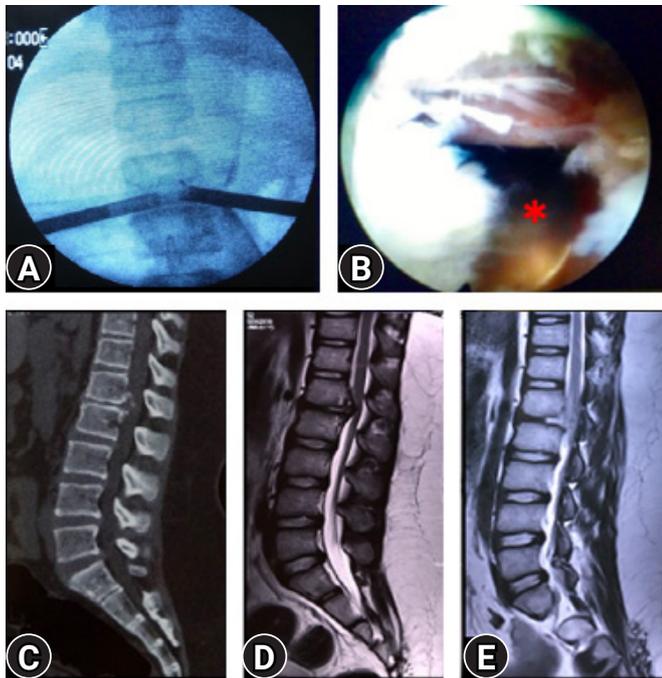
(A) Image intensifier view of a bilateral transforaminal endoscopy with two working ports. (B) The one side view showing the opposite working sheath with removed ventral stenosis and with neural fall back suggesting the EPD (End point decompression). (C, D) CT scan and MRI showing calcified ventral disc and posterior longitudinal ligament in a case for Conus syndrome L1-L2 with paraparesis. (E) Post-operative MRI conforming the extend of decompression. Patient recovered completely in two weeks' time and 7 years follow-up.
